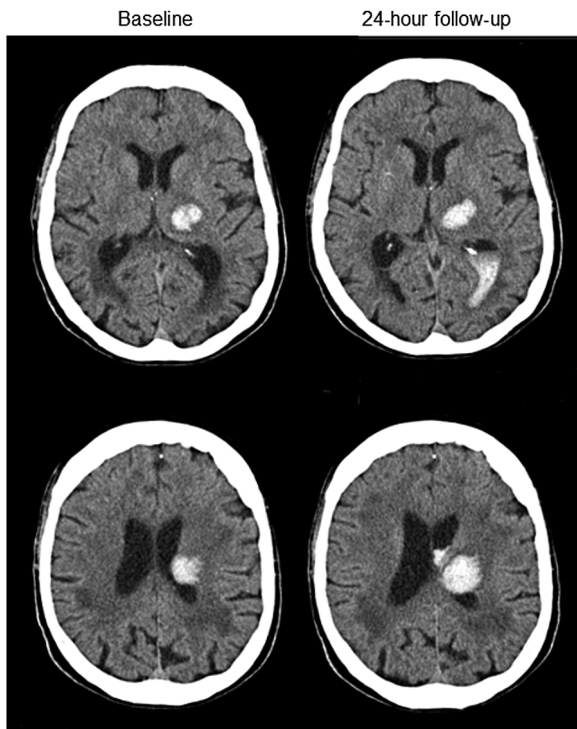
Baseline and 24 h follow-up CT images from a selected patient to demonstrate delayed intraventricular haemorrhage.
